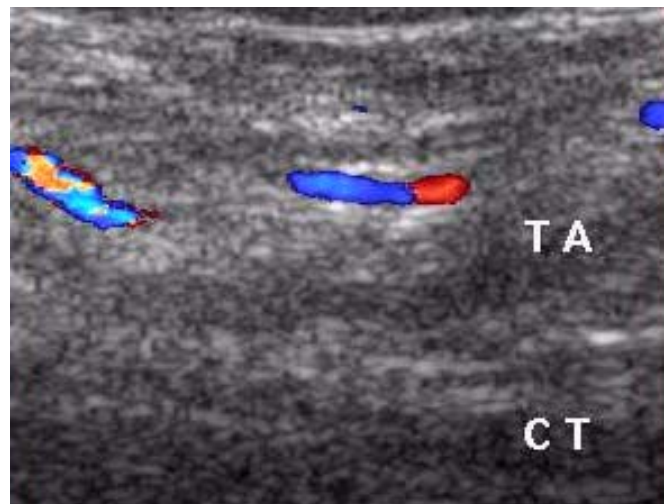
Once the region of the deep inguinal ring is identified, the probe is turned into an oblique plane angling downwards and medially towards the pubic tubercle. CDI shows the testicular artery (TA) confirming that the probe lies along the line of the inguinal canal. The conjoint tendon (CT) forms the posterior wall of the inguinal canal.
